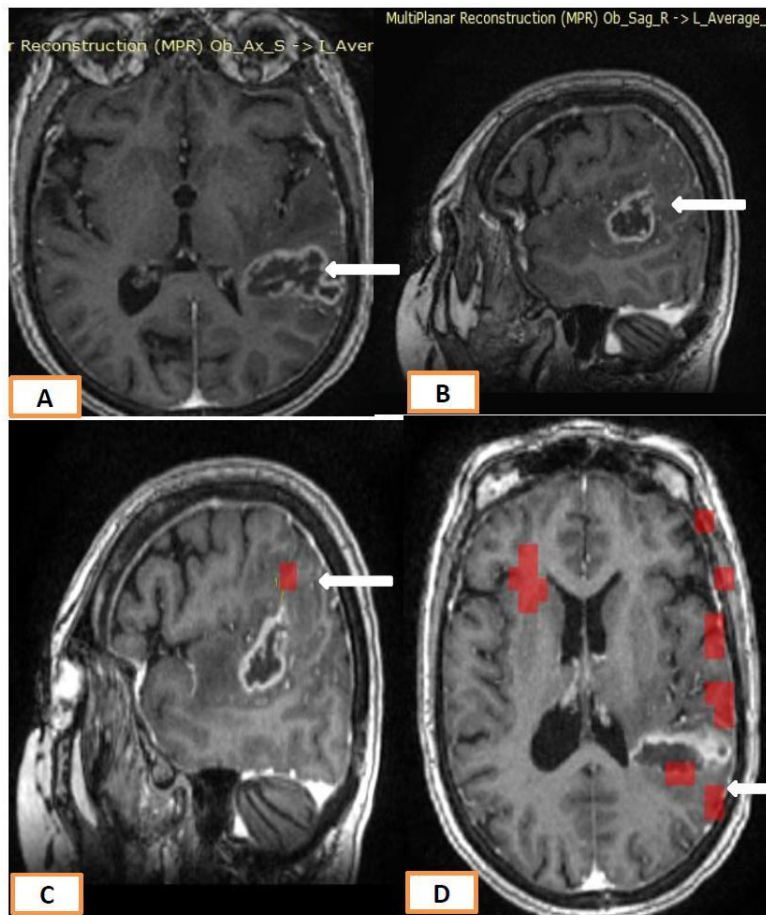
A 56 year's old female patient, complained from aphasia, conventional MRI axial and sagittal T1WI with contrast (A&B) revealed left parietal intra-axial SOL showing heterogeneous mainly marginal contrast enhancement with internal irregular non enhancing area, it is seen surrounded by moderate vasogenic edema, both exerts mass effect in the form of effacement of the overlying cortical sulci and compression of occipital horn of the left lateral ventricle GBM (white arrows). Functional MRI Language paradigm revealed that the broca's area (C) seen away from the tumor LAD > 2 cm (white arrow), while the wernike's area seen with in the tumor mass (D) (white arrow).
